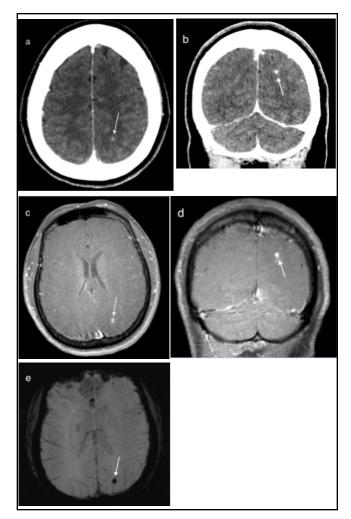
A head CT scan revealed a 4-mm contrastenhancing focus in the left parietal lobe (a, b). Subsequent MRI demonstrated the solitary lesion (c, d). A susceptibilityweighted sequence (e) revealed that the lesion was associated with hemorrhage, further raising concern for metastatic choriocarcinoma. No other intracranial metastases were identified.
